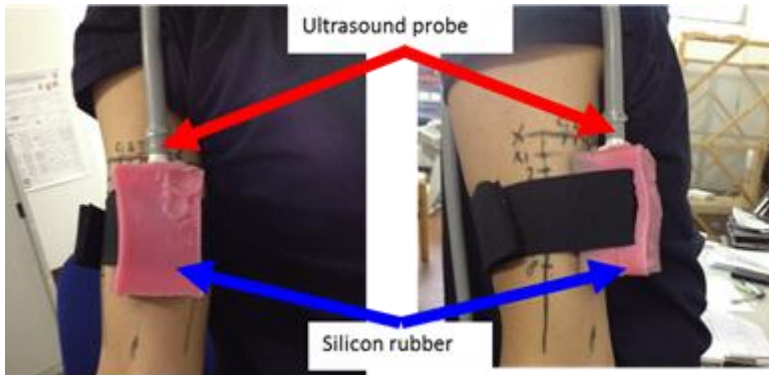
The ultrasound probe was fixed on the participant's upper arm using an elastic band.
